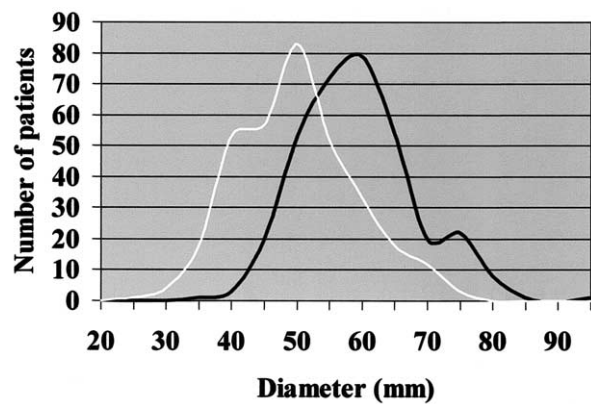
Measurement of maximal aneurysm diameter with CT^{\max} (black line) (56.9 mm) compared with US^{\max} (white line) (47.4 mm). CT^{\max} significantly greater than US^{\max} ($P < .001$).
